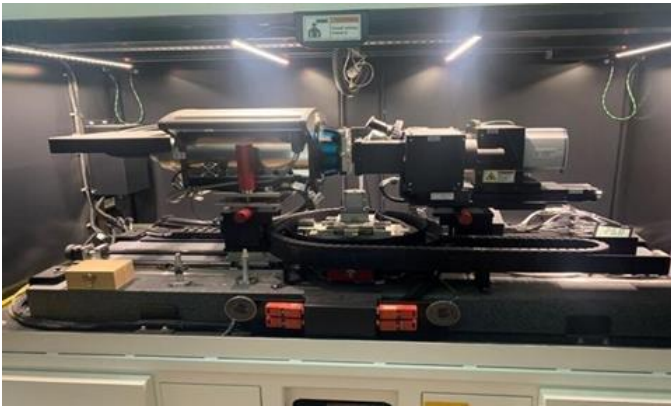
Micro Computed Tomography Device (Zeiss X Radia Versa)
